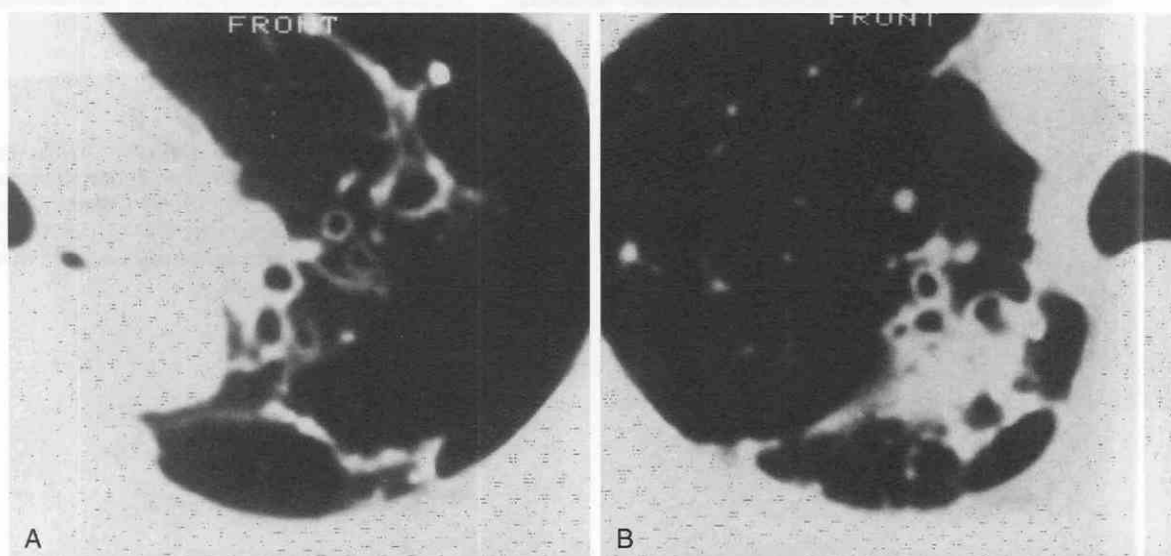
A and B, CT features of chronic fibrocalcific tuberculosis (TB) include scarring, calcified granulomata, bronchiectasis, architectural distortion, and fibrotic masses.
